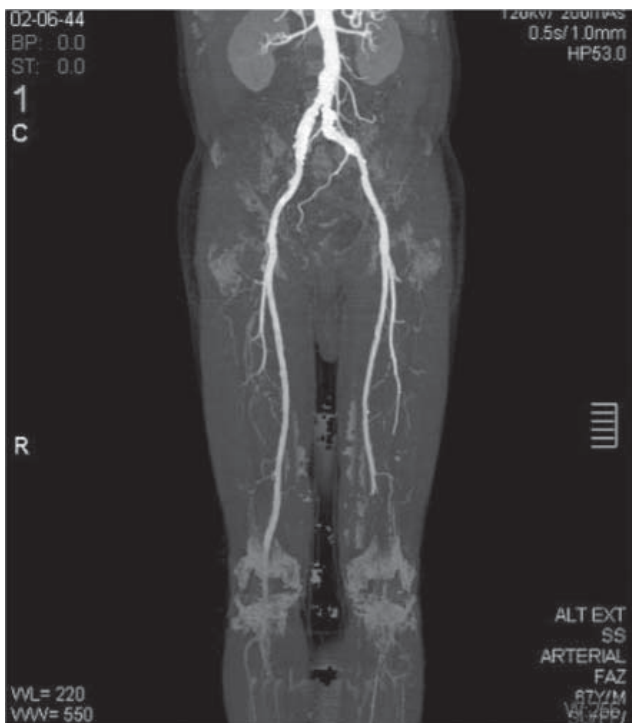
Thrombosed PA aneurysm was observed on computed tomography angiography.
